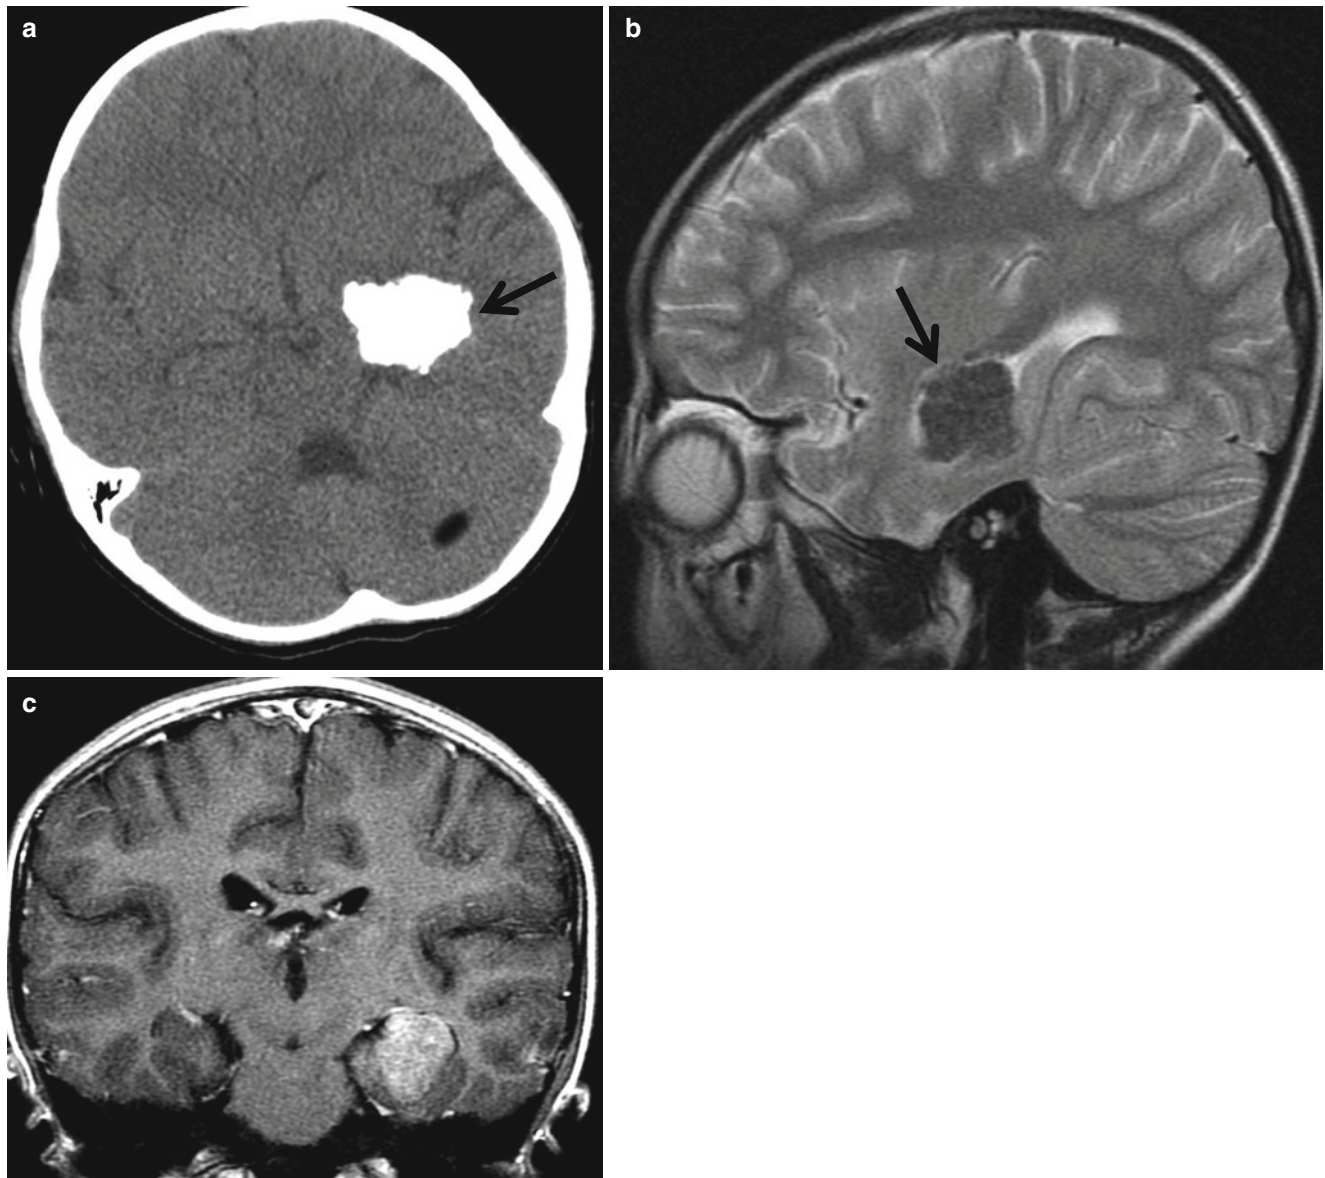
Choroid plexus papilloma in a 6-year-old boy. (a) Precontrast CT shows densely calcified mass (*arrow*) in the left temporal lobe. (b) Sagittal T2-weighted image reveals hypointense mass within the temporal horn. (c) The mass is enhanced on a postcontrast image
